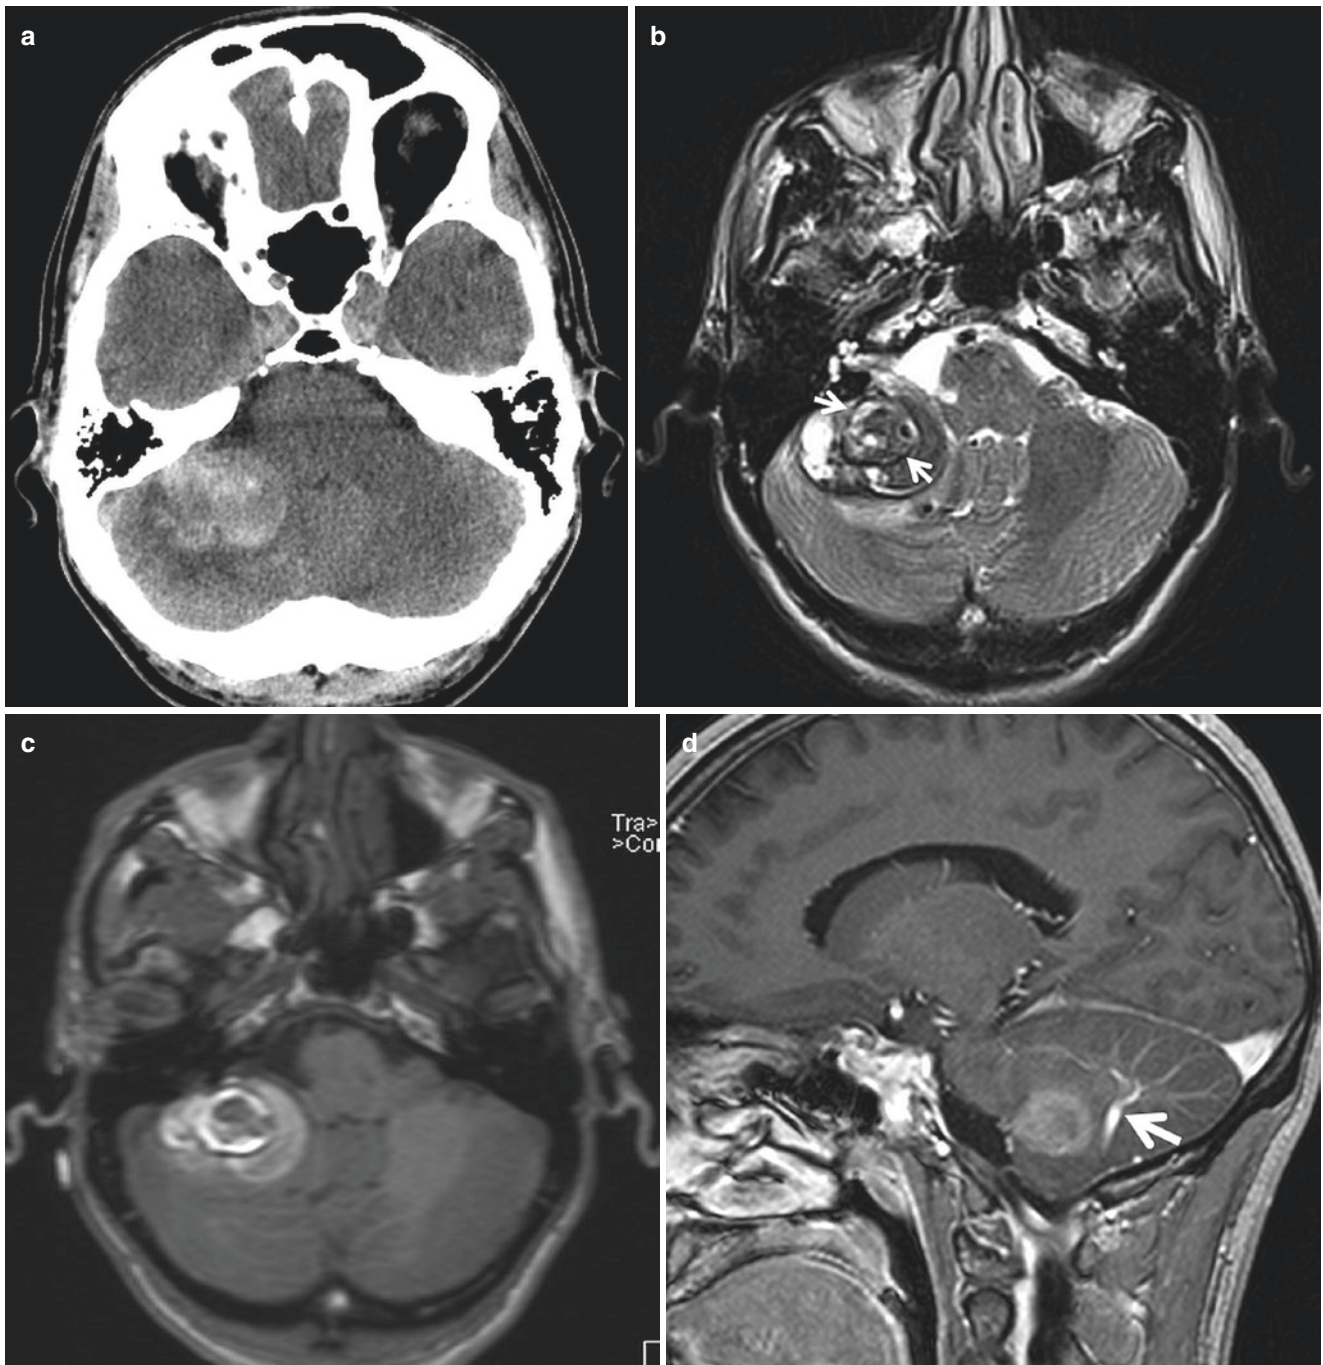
Cavernous malformation with associated DVA. (a) NCCT shows right cerebellar hemorrhage. Axial T2 (b) and T1 (c) MRI demonstrates a right cerebellar intraparenchymal hematoma with heterogeneous T2 and T1 signal. Note an ovoid lesion with a hemosiderin ring
